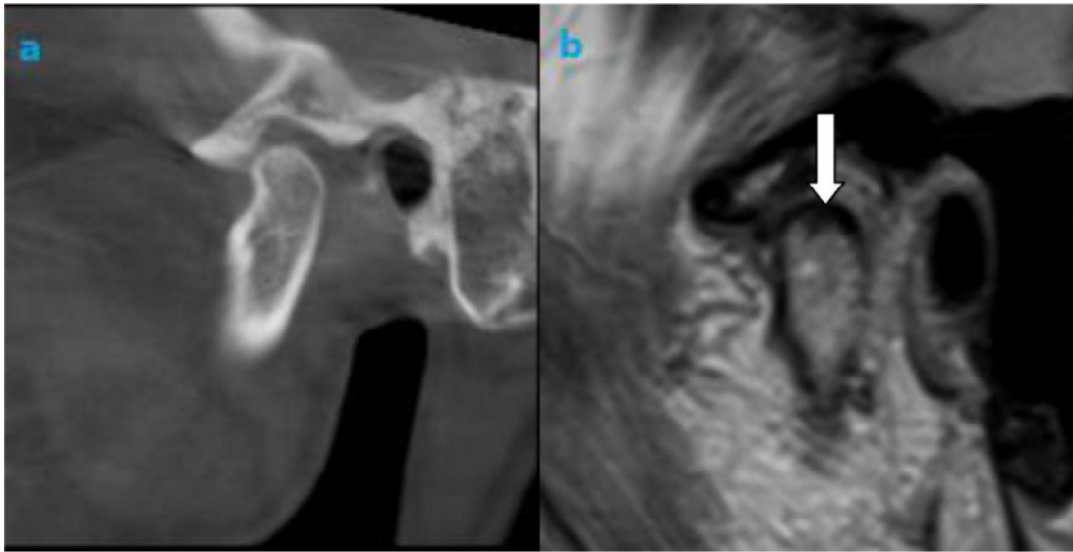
A 41-year-old woman with chief complaints of crepitus, pain and limited mouth opening. (a) Cone beam CT revealed no abnormality of the left condylar head, whereas (b) erosion was suspected on the corresponding sagittal proton density-weighted MR image (arrow).
